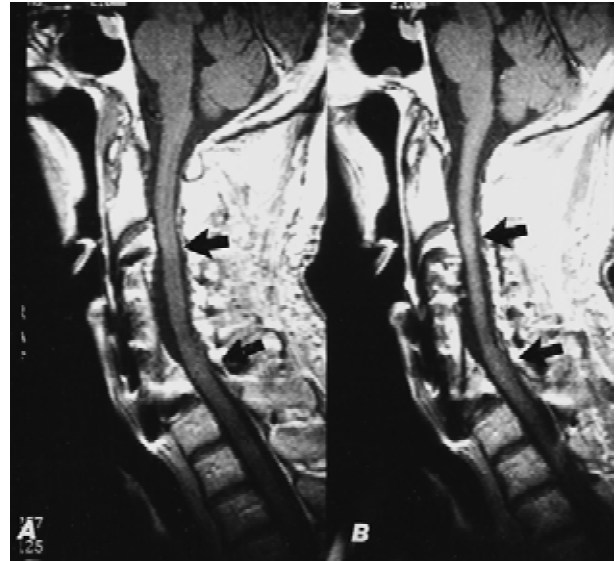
The 3-month postoperative midline and paramedian sagittal T1-weighted MR study confirms adequate decompression after C3–C7 ACF with Orion plate placement and C3–T1 PWF (case 2). A: A midline MR shows adequate cord decompression (arrows) 3 months after operation. B: The paramedian sagittal T1-weighted MR also readily confirms the extent of cord decompression (arrows).
